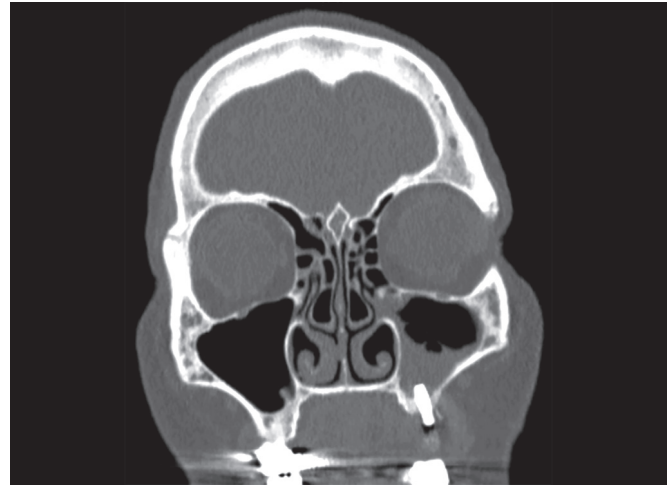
Noncontrast CT scan of the sinuses with an acute left odontogenic maxillary sinusitis. Patient has an air fluid level in the left maxillary sinusitis with a dental implant placed into the floor of the maxillary sinus. Patient required maxillary antrostomy to clear the infection.
